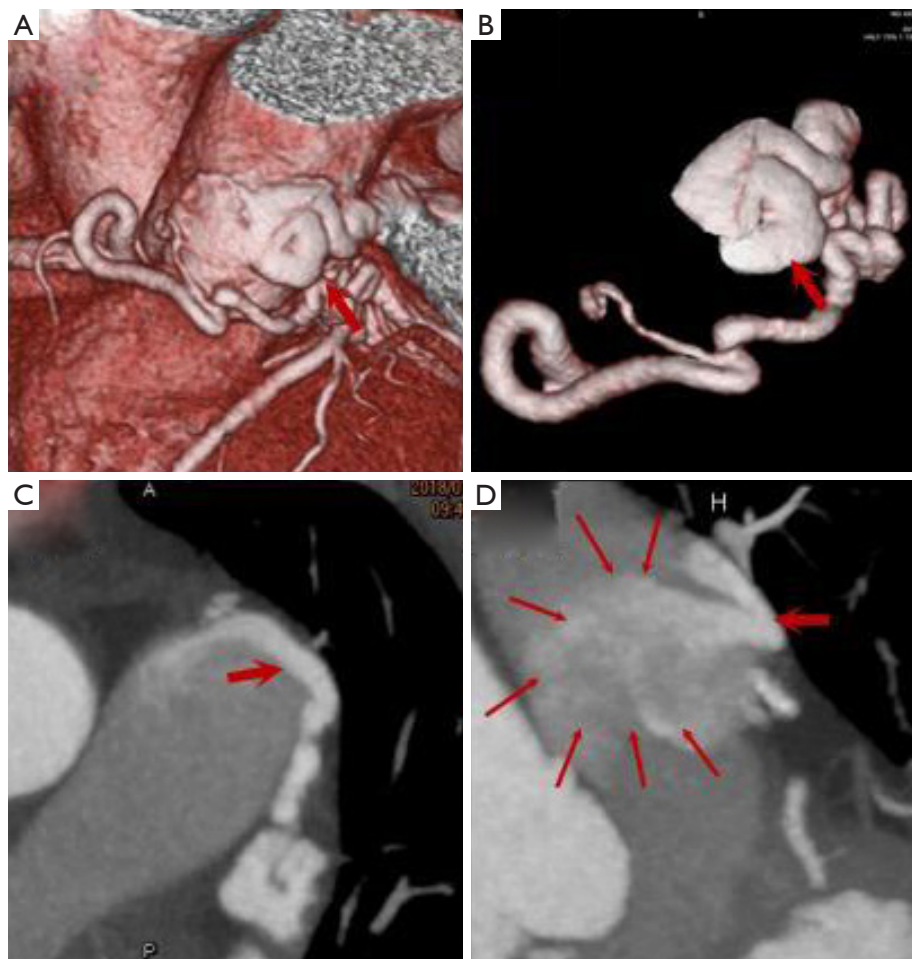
An 81-year-old female with chest distress and pain. VR images (A,B) show worm-like tortuous dilated fistula vessels simultaneously originated from both the RCA and LAD, accompanied with focal aneurysm formation (thick red arrow). CT MPR images on the axial plane (C) a fistula vessel draining into the left lateral wall of MPA (thick red arrow), and MPR image on the coronal plane (D) a huge drainage site with an average diameter of 5.2 mm, and a jet of contrast from supplying artery to MPA forming a typical pierced sign (thick red arrow) and smoke sign (thin red arrow). VR, volume rendering; RCA, right coronary artery; LAD, left anterior descending artery; MPR, multiplanar reconstruction; MPA, main pulmonary artery; CT, computed tomography.
